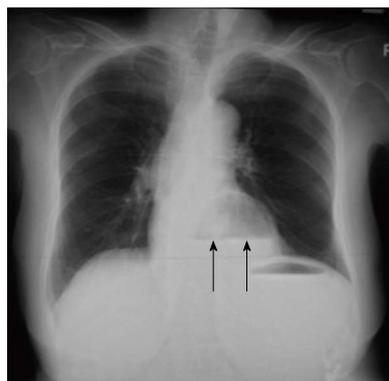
A chest X-ray film at admission, revealing air in the dilated stomach associated with air-fluid level (arrows), which was dislocated into the chest.
